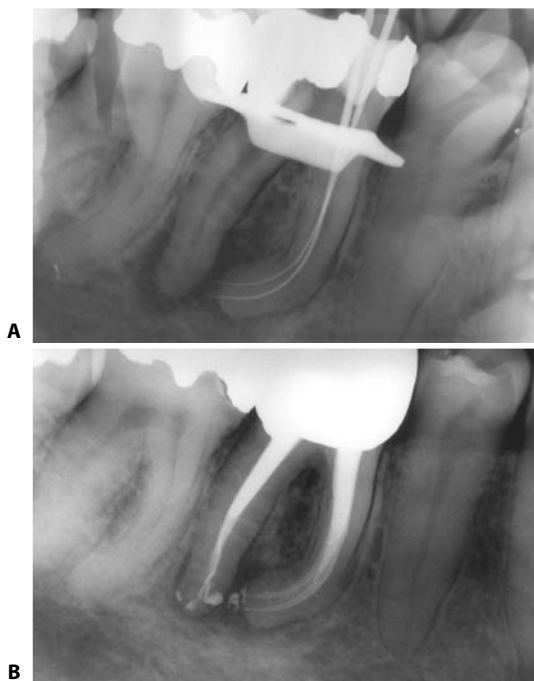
A, B. A lower first molar prepared and filled with warm gutta-percha to the radiographic terminus. Note that the instruments often pass slightly beyond this terminus encroaching of the periodontal ligament, thus, addressing the entire root canal system. Note that numerous secondary and tertiary canals have been obturated (Scianamblo 1992).
